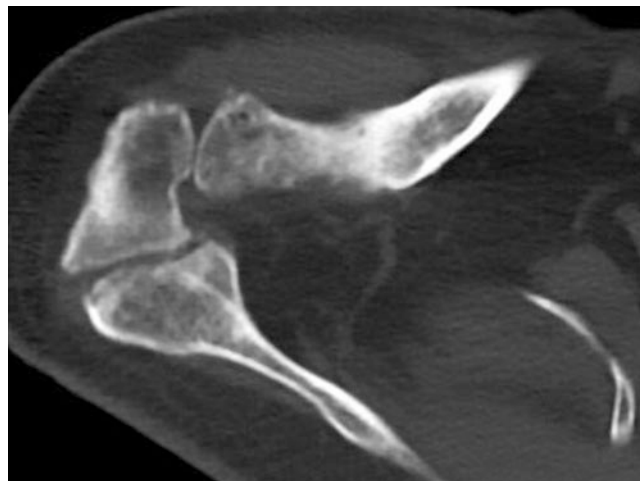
Axial CT demonstrating a right sided acromion stress fracture
